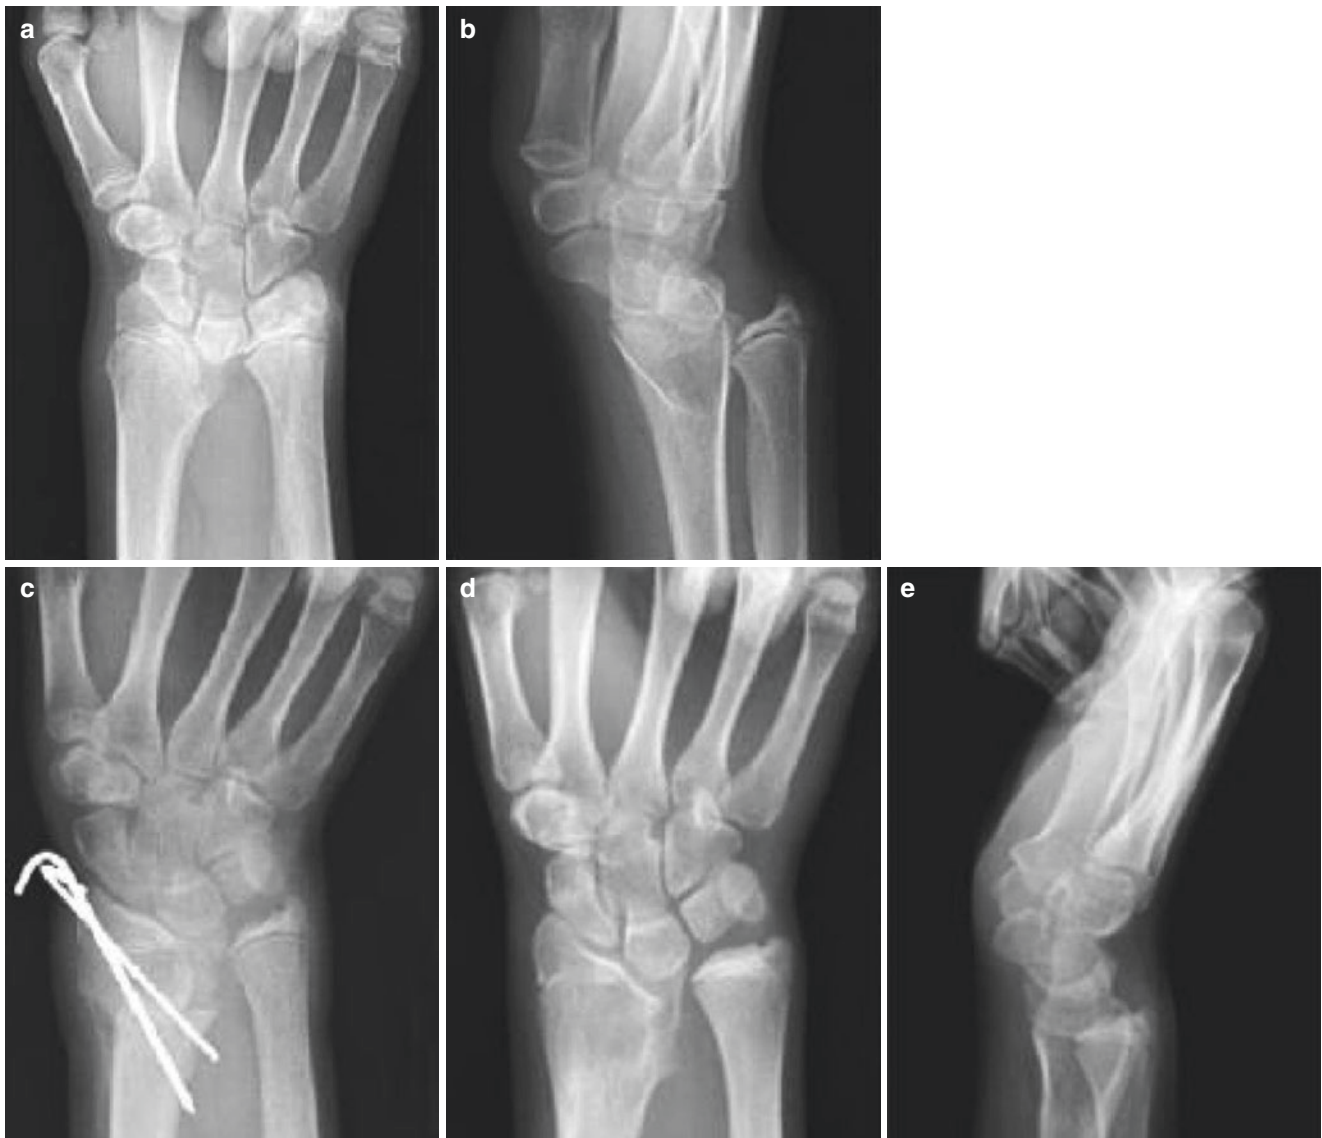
Arch-shaped osteotomy at the distal end of radial bone. (a, b) X-ray findings before operation. (c) Perform arch osteotomy at the radial bone, and utilize the Kirschner silk to fix them via the radial styloid process. (d, e) Radial bone union 6 weeks after operation
